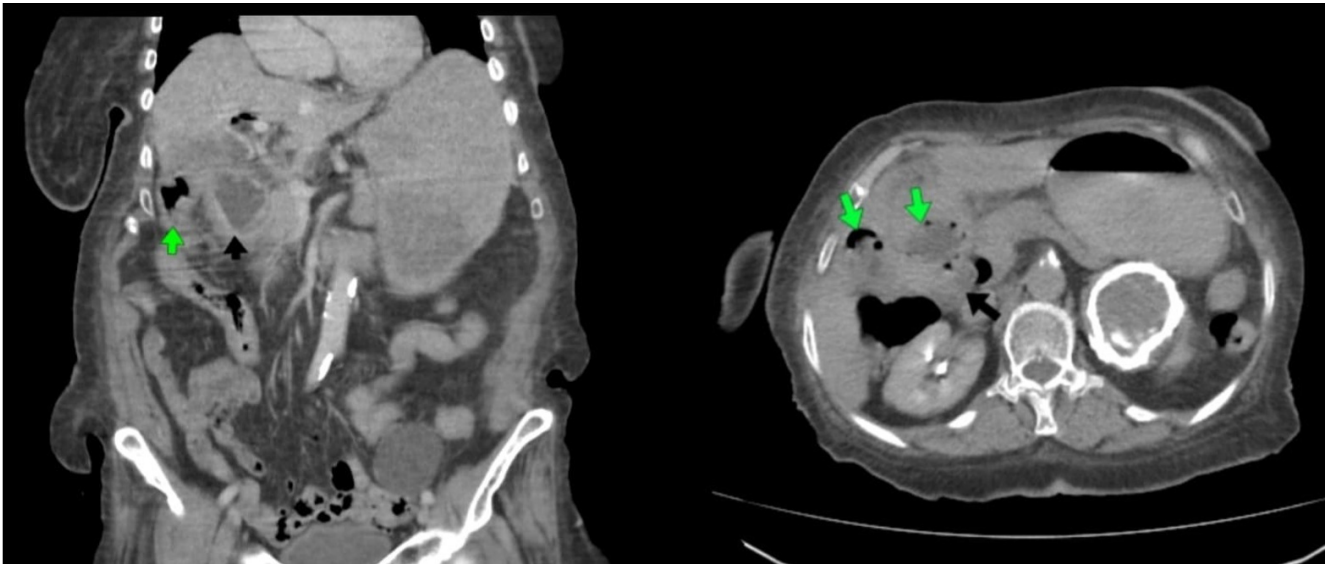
Multislice CT of the abdomen with oral and IV contrast showing a partially distended, irregular gall bladder containing multiple gas vacuoles (green arrows), which are seen compressing the second part of the duodenum (black arrows) with a fistulous track in between, excreting proximal dilation of the stomach. Obvious pneumobilia is also seen.
